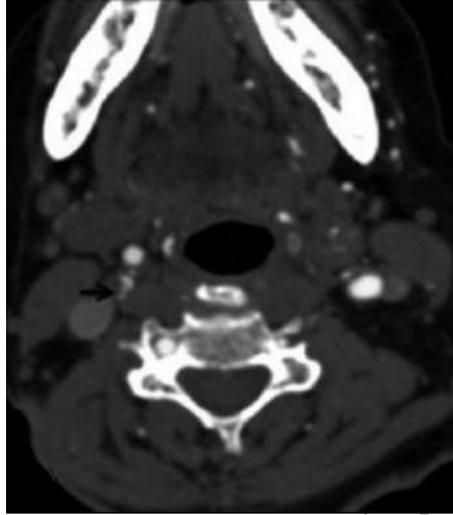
CT image showing ulcerations in right carotid bifurcation plaque (white arrow).
